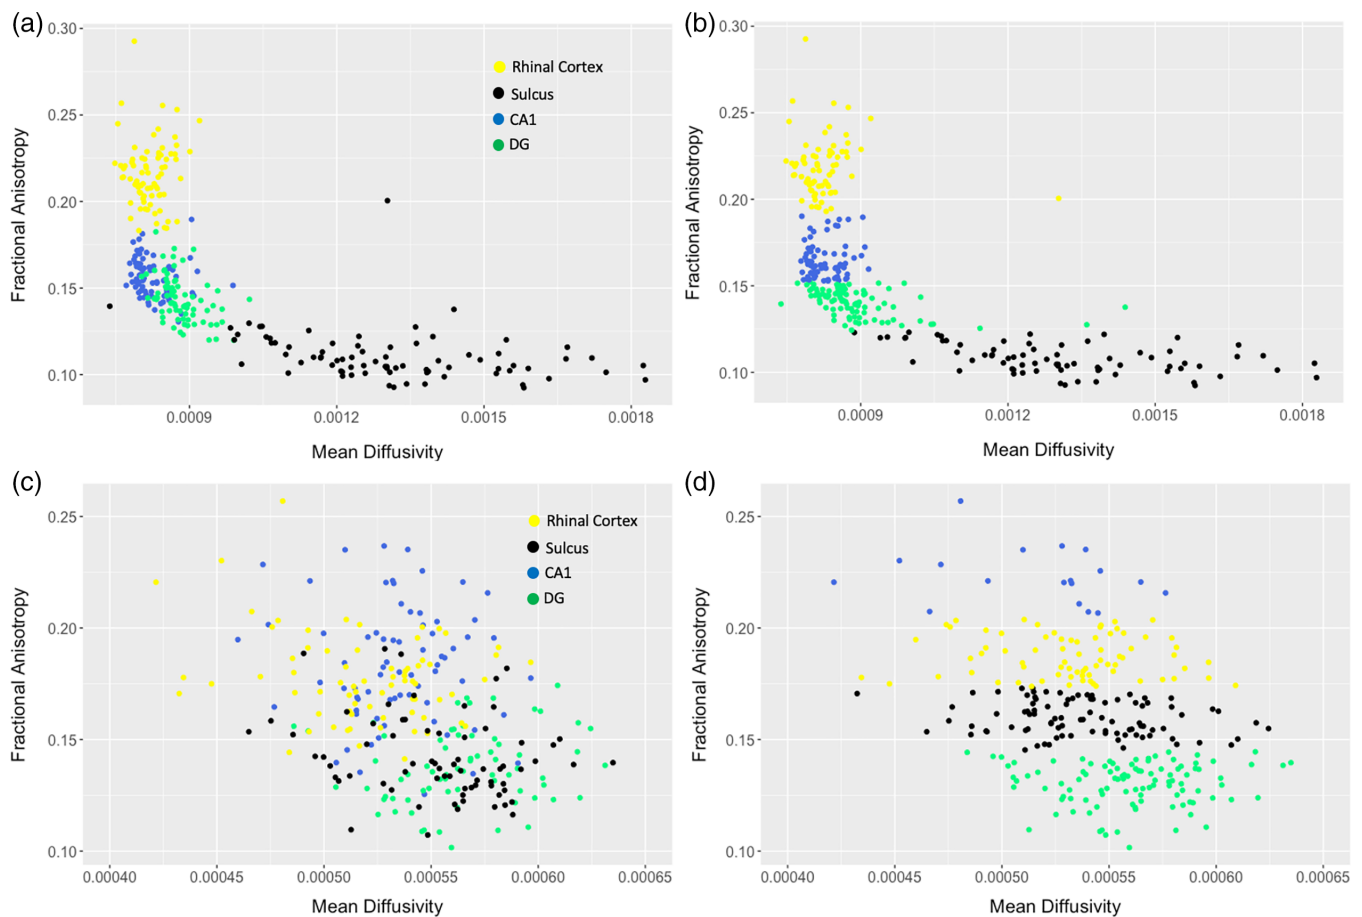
(a) Shows the FA and MD data for each area of interest: CA1 (in blue), DG (in green), rhinal cortex (in yellow), and sulcus (in black) derived from the *high-resolution DWI sequence*. (b) Shows the same data points categorized into four clusters via unsupervised K-means clustering. We note the large degree of visual overlap (normalized mutual information score = 0.623). (c) Shows the actual FA and MD data plotted for each area of interest: CA1 (in blue), DG (in green), rhinal cortex (in yellow), and sulcus (in black) derived from the *whole brain DWI sequence*. (d) Shows the same data points clustered into four clusters using unsupervised K-means clustering. Here we note the minimal degree of overlap between the actual data and predicted data identities (normalized mutual information score = 0.242)
